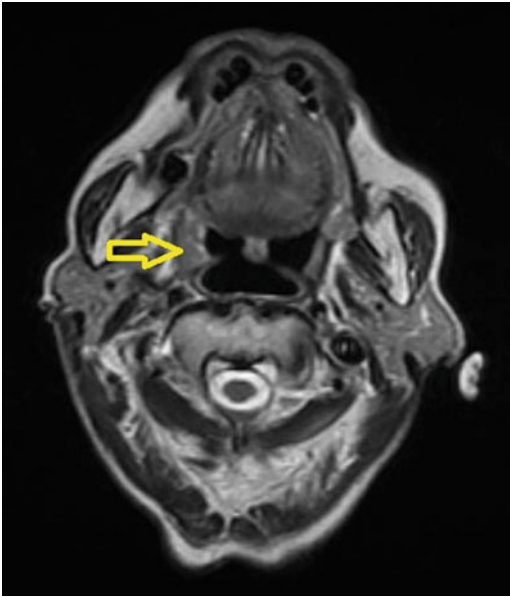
Contrast-enhanced T1 MRI image showing thickening of the tonsillar fossa (arrow) suggestive of an early tumor
